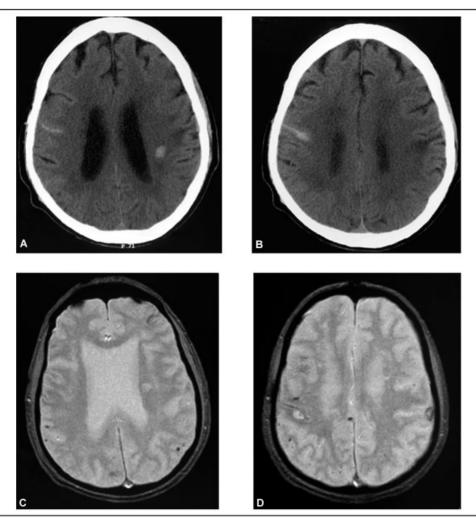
Computerized tomography (CT) scans (A, B) of the proband showed the presence of a small, right parietal intraparenchymal hemorrhage associated with a subarachnoid hemorrhagic effusion. An additional small intraparenchymal hemorrhagic lesion was observed in the left corona radiata. T2-weighted magnetic resonance imaging scans (C, D) similarly disclosed the presence of the same intraparenchymal hemorrhages, together with multiple cortical hypointensities particularly in the parietal lobes, corresponding to old hemorrhagic foci.
